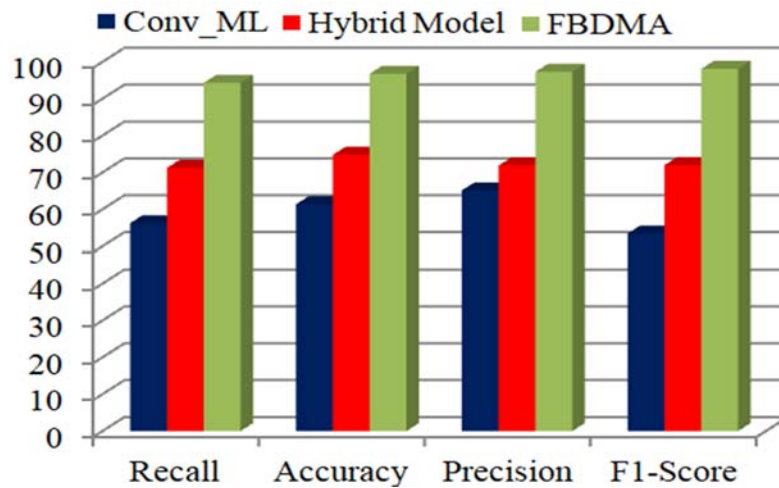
Performance on training of Br35H Dataset for the Brain Tumor MRI Images
